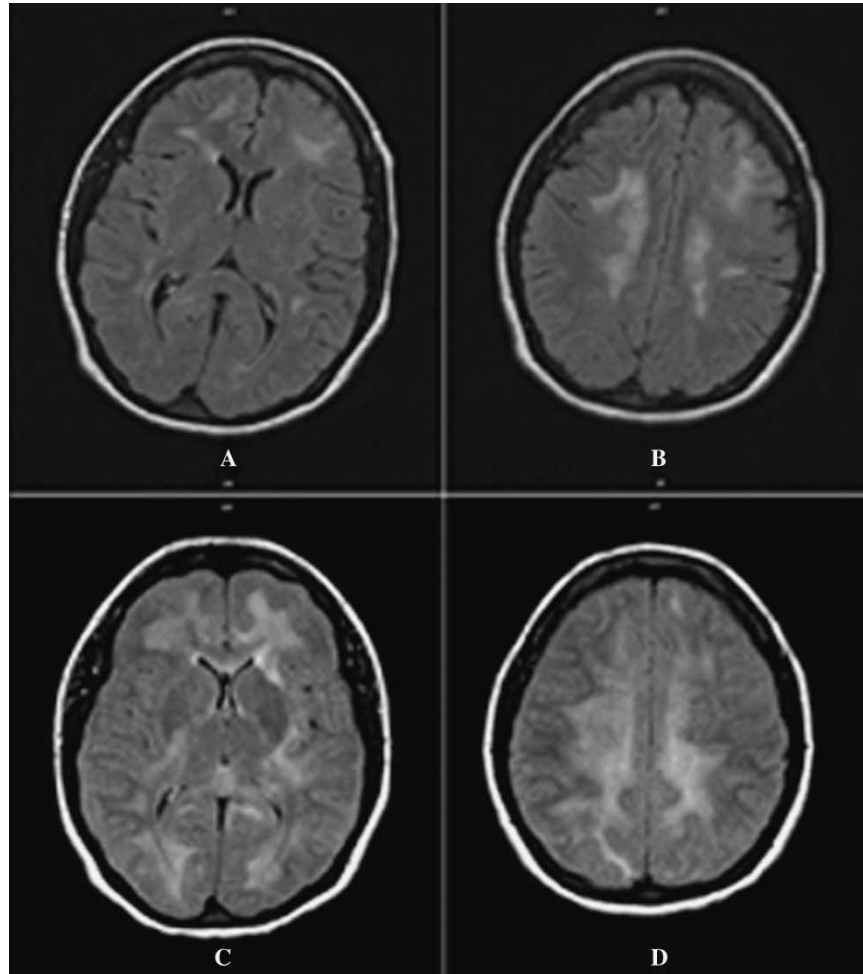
Brain MRIs from June 2007 (A and B) and December 2007 (C and D). Fluid-attenuated inversion recovery sequence images on MRI from June 2007 (A and B) show diffuse hyperintense signal abnormalities in both cerebral hemispheres. A repeat (C and D) in December 2007 shows that these lesions are more extensive.
